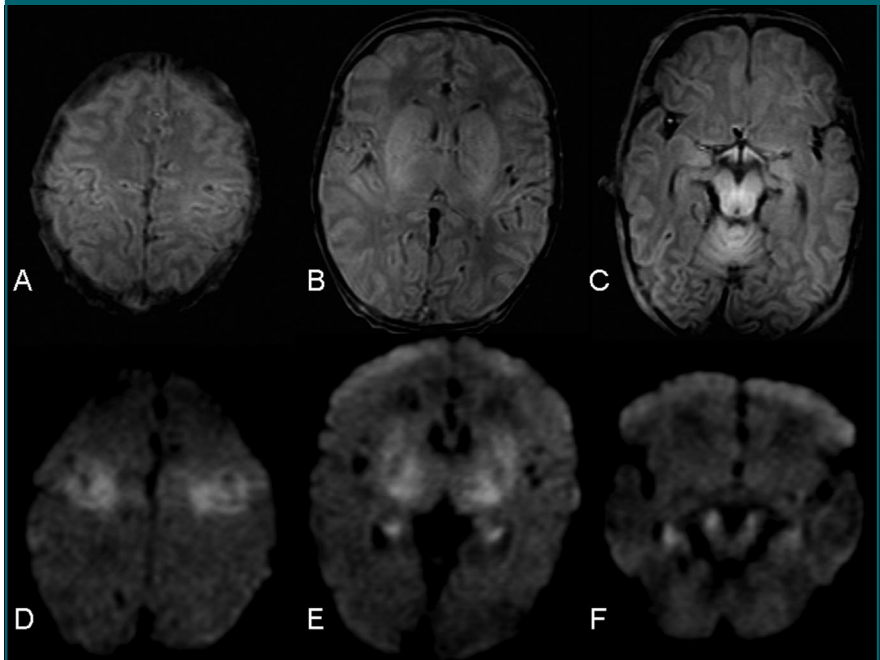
MR images at day 3 in an infant with basal ganglia and central cortex pattern of cerebral damage and a poor motor outcome. *A–C*, T1-weighted MR images with absence of normal high signal intensity in the internal capsule. *D–F*, DW images ($b = 1000 \text{ sec}/\text{mm}^2$) show hyperintense signal in the Rolandic cortex, basal ganglia, hippocampus, and cerebral peduncle.
